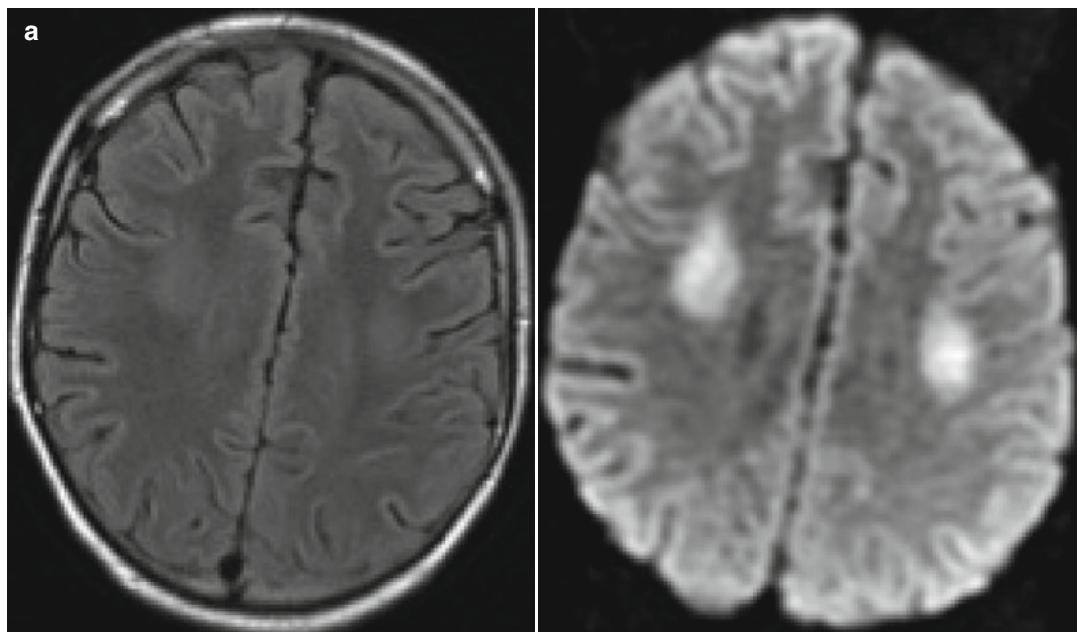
Methotrexate toxicity. (a) Acute methotrexate toxicity. A 17-year-old patient with diffuse large B lymphoma, presenting with headaches and confusion within 6 days intrathecal methotrexate treatment. Discrete bilateral FLAIR hyperintensity (*left*) in the corona radiata and intense well-delimited hypersignal on diffusion-weighted images (*right*). The patient fully recovered from this event. (b) Subacute post-methotrexate leukoencephalopathy in a patient treated 2 months previously with aracytin, dasatinib, and intrathecal methotrexate. FLAIR images immediately before treatment (*left*) show minimal microvascular leukopathy and discrete right subdural collection.
